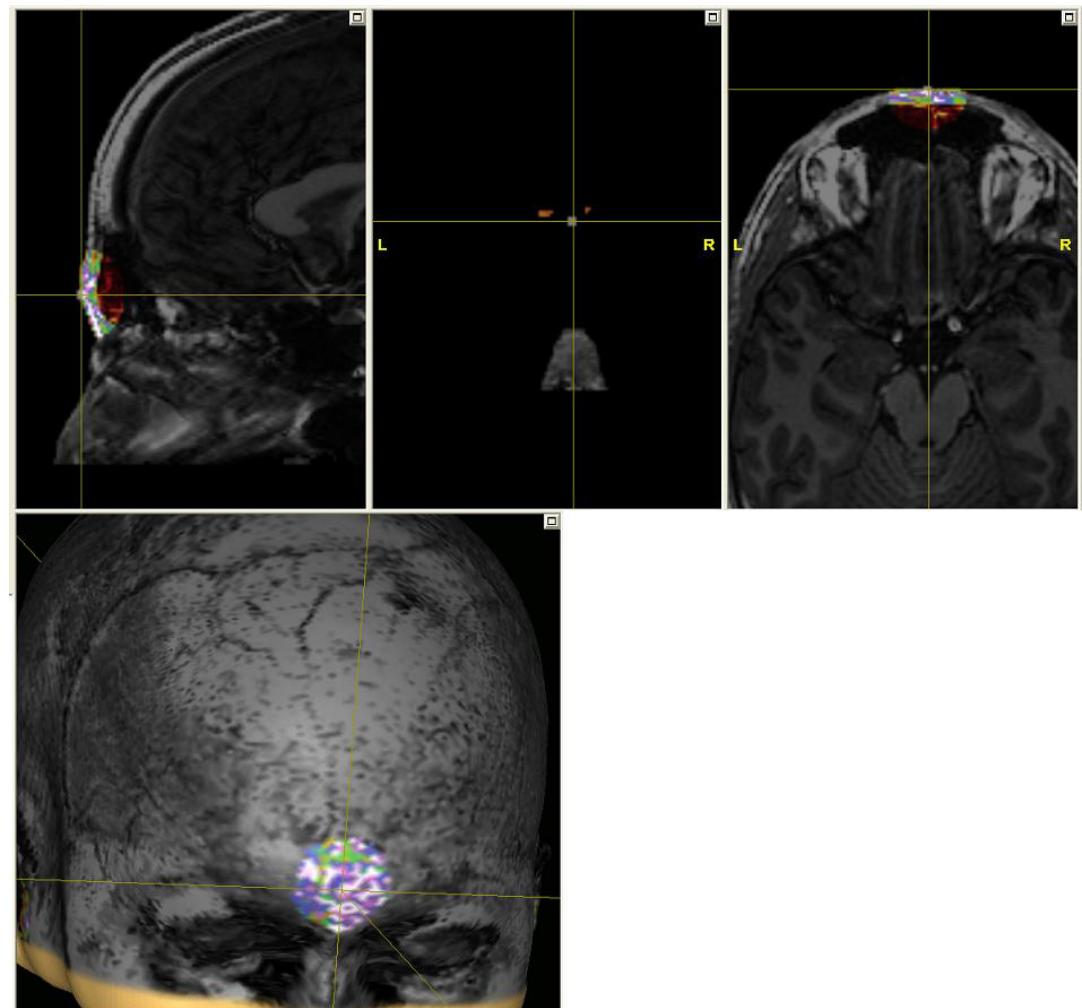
Rainbow colormap: Location of the nasion landmark in the MR images and 3D head
